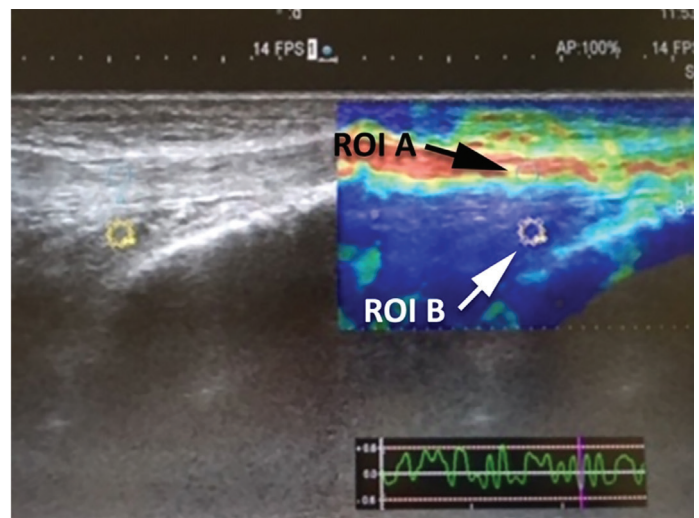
Location of the two ROIs 1 cm proximal from patellar insertion area. Selected quadriceps tendon area (ROI A) and the prefemoral fat pad area (ROI B). Strain elastography ratios (B/A) were calculated by the elastography software of the ultrasonography device
